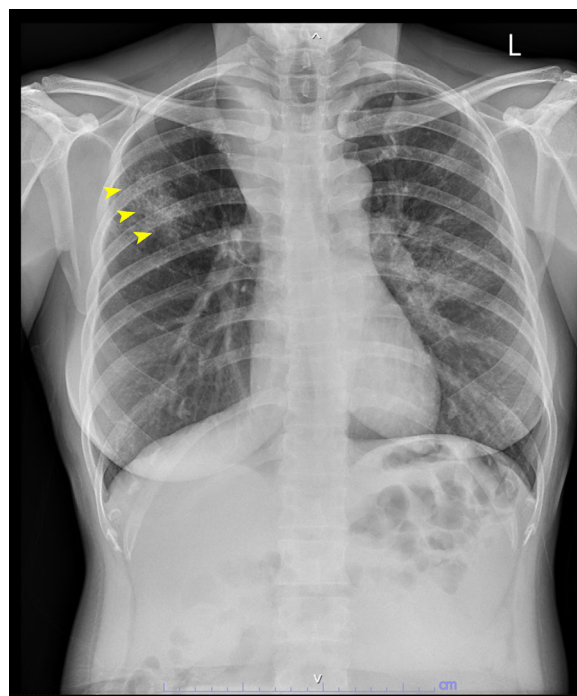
Pre-intubation chest radiograph (posteroanterior view) showing right upper lobe infiltrations (arrowheads)
